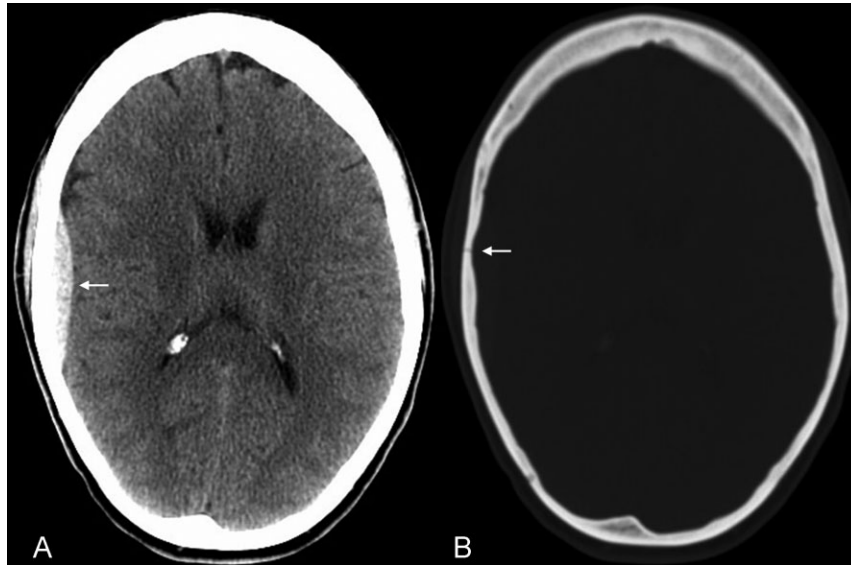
Acute epidural hematoma with an associated linear nondisplaced skull fracture. (A) The axial computed tomography image displayed in the brain window shows a small right temporal epidural hematoma (arrow). (B) The computed tomography scan displayed in the bone window shows a subjacent linear nondisplaced fracture of the temporal squamosa (arrow).
